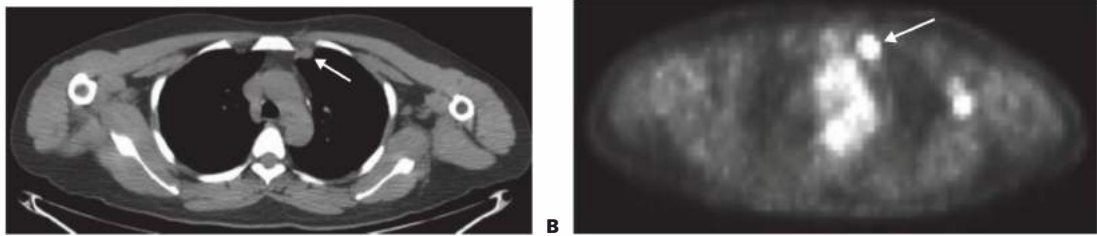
• A. Chest CT scan demonstrating enlarged left internal mammary node. B. PET scan image shows fluorodeoxyglucose (FDG) uptake in the left internal mammary node. (Courtesy of Stephen Seiler, MD, University of Texas Southwestern Medical Center.)
